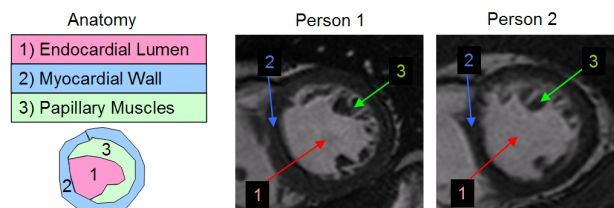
Layout of the left ventricular anatomy in the short-axis plane of two Cardiac MRI images from separate individuals. The anatomy displays a rich structure that varies considerably between individuals.
